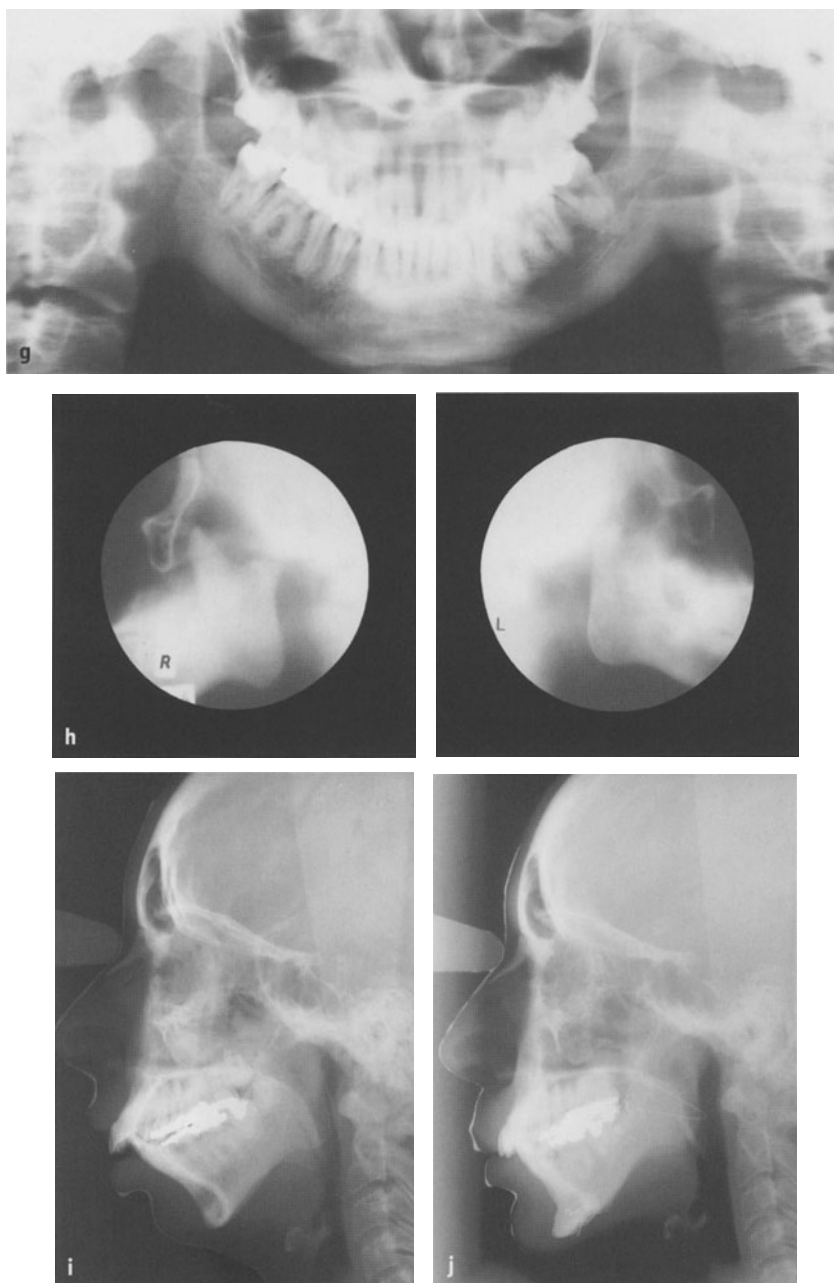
Case of severe symmetrical microretromandibulism with retro- and hypogenia, due to bilateral condylar destruction as a consequence of untreated bilateral luxation of the mandible in infancy. g Panoramic radiograph in closed position demonstrating the very small mandible with little remnants of the condyle only, and with the posterior border of the rami directed toward the articular prominence on the right side and in front of it on the left side. h Right and left TMJ-ramus tomograms showing shortness of ramus length directed towards and in front of the articular eminence with little remnants of the condyles and their neck. i, j The lateral cephalograms before and 2 years after final surgery demonstrate the shortness and the achieved length of the horizontal rami and prominence of the chin and the change in the angulation of the lower front teeth
